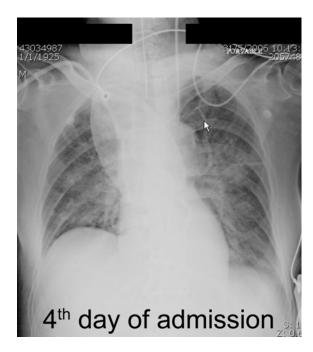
Chest roentgenogram on fourth day of admission shows a mixture of reticular and alveolar patterns of pulmonary infiltrate on both lungs
